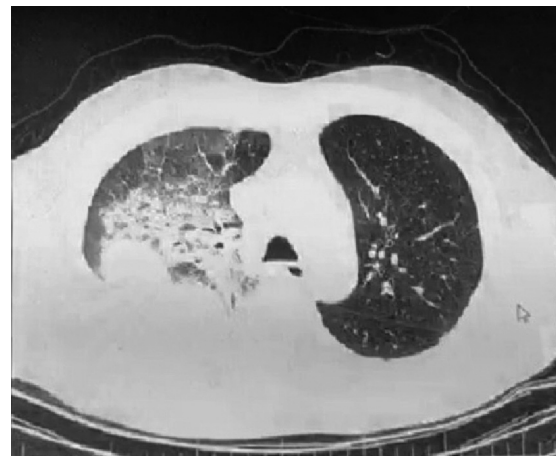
CT scan performs GGOs in right lower and middle lobes.
